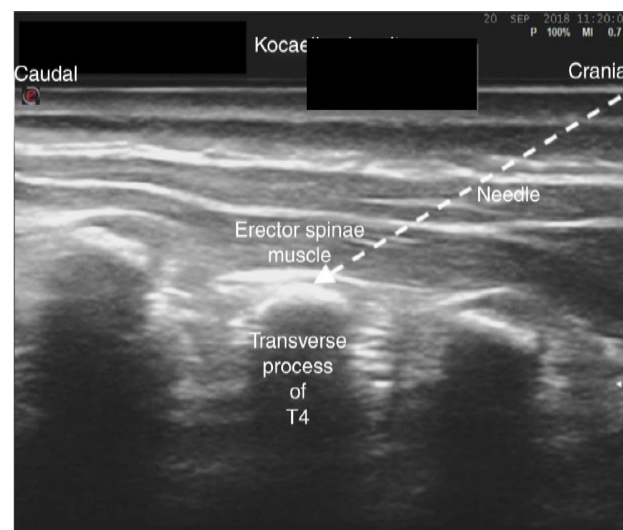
Ultrasound anatomy and injection site for Erector Spinae block
